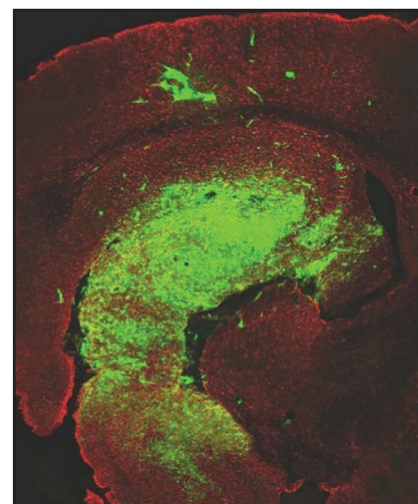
GBM cells (in green) spread diffusely, and Pruitt¹⁶ that showed, using computed tomography (CT), 78% of recurrences were within 2 cm of the margin of the initial tumor bed, and 58% were within 1 cm. This pattern was validated by Wallner et al.¹⁷ These data are the basis for the definition of the boost to GTV treated to higher doses (eg, 60 Gy). According to the EORTC, only a treatment volume receives 60 Gy in 30 fractions. The GTV corresponds to the surgical resection cavity plus any residual enhancing tumor (postcontrast T1-weighted MRI scans); the CTV comprises the GTV plus a margin of 20 mm; and finally, PTV is equal to CTV plus a margin of 3-5 mm.
